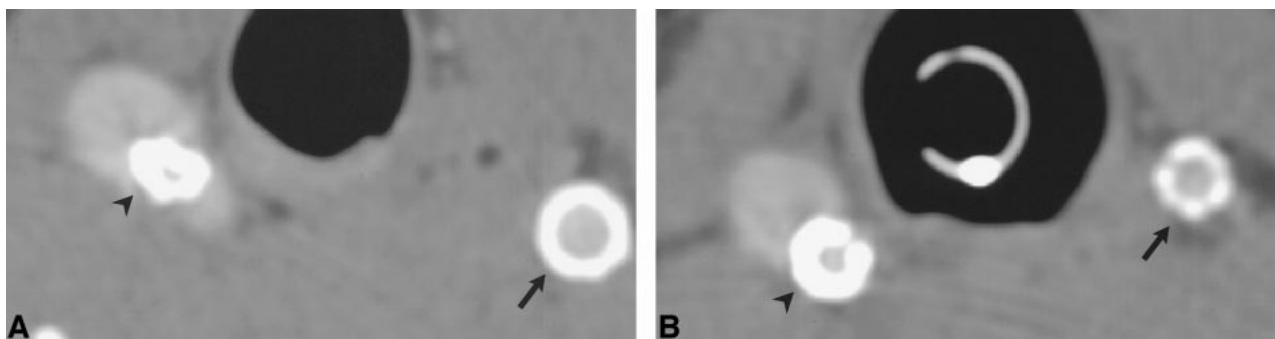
CT angiographic source images of aneurysm treated with stents and stent-grafts show differences in artifacts produced by different device compositions.
